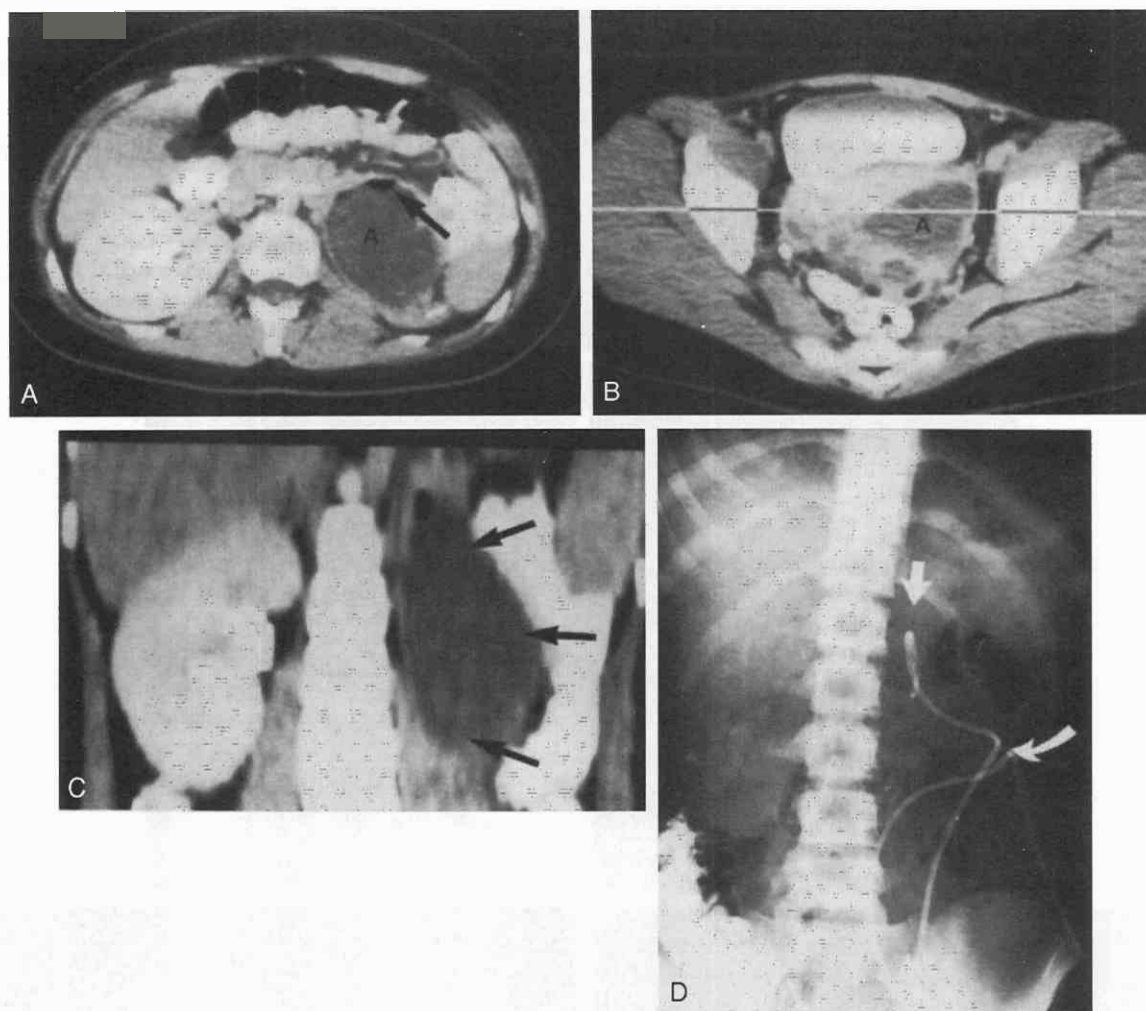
A, CT scan through the midabdomen shows a large abscess (A) in the retroperitoneum, containing some gas (arrow). B, The lowest portion of the abscess (A) extends into the pelvis behind the left adnexa of the uterus. C, Coronal reconstruction shows a long abscess (arrows) extending through the retroperitoneum. D, Plain film shows placement of two catheters entering from the middle of the cavity (curved arrow), extending to the top and bottom of the cavity (arrows).
